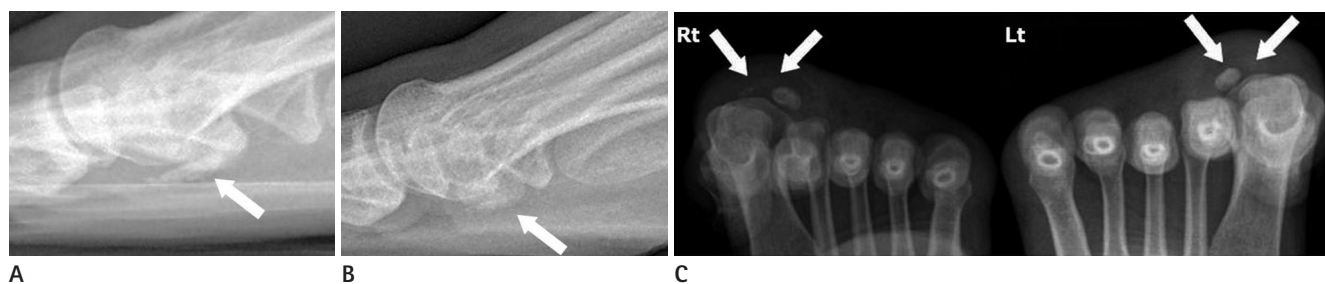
Plain radiographs of the right foot who a 33-year-old woman with plantar pain to the right first metatarsophalangeal joint. A comparison of two radiographs at interval changes of a year; the medial sesamoid collapsed and had more areas of demineralization with fragmentation. A. Initial right lateral ankle radiograph at the outside hospital demonstrates flattening of the medial sesamoid with sclerosis (arrow). B. A year after initial lateral radiograph demonstrates a more collapsed medial sesamoid with increased areas of demineralization (arrow). C. An additional sesamoid view demonstrates the absence of the left medial sesamoid (arrows) and hypoplasia of the right medial sesamoid (arrows) with fragmentation and adjacent soft tissue swelling.
